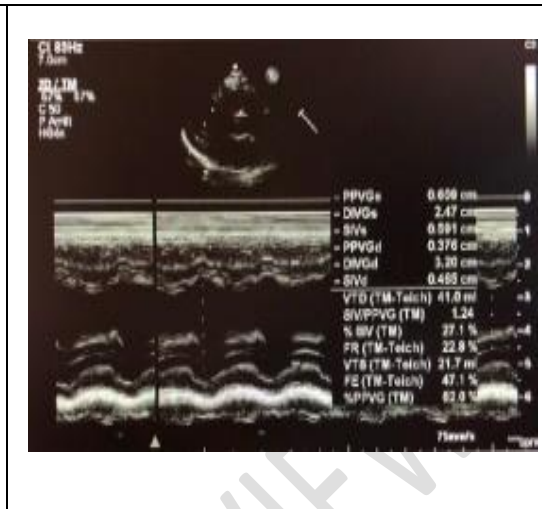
Echocardiography after treatment
